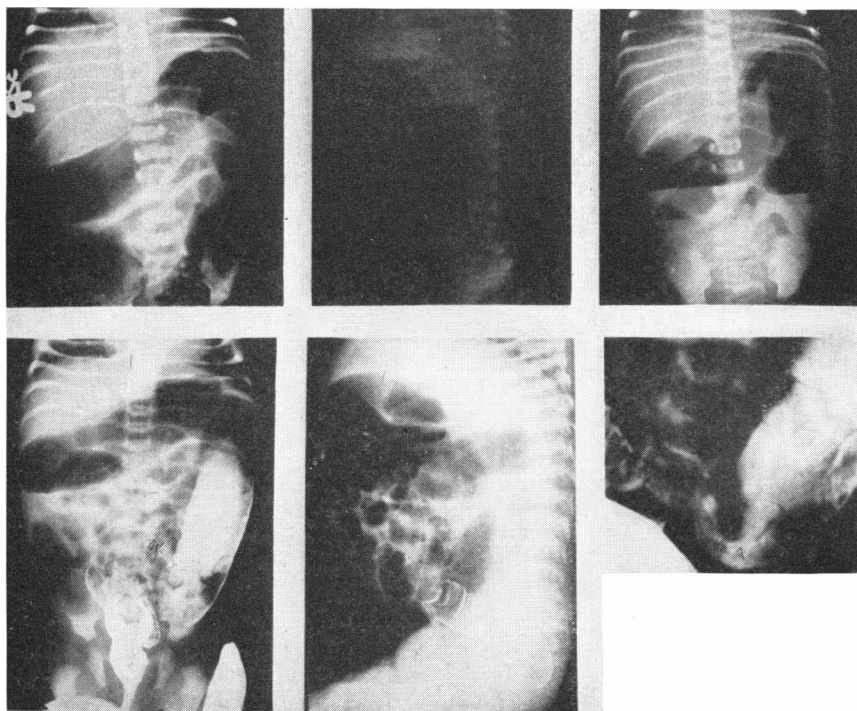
The upper 3 plain roentgenograms of the abdomen in the supine, erect lateral and erect antero-posterior projections were taken in a 3-day old infant and demonstrated intestinal obstruction.
